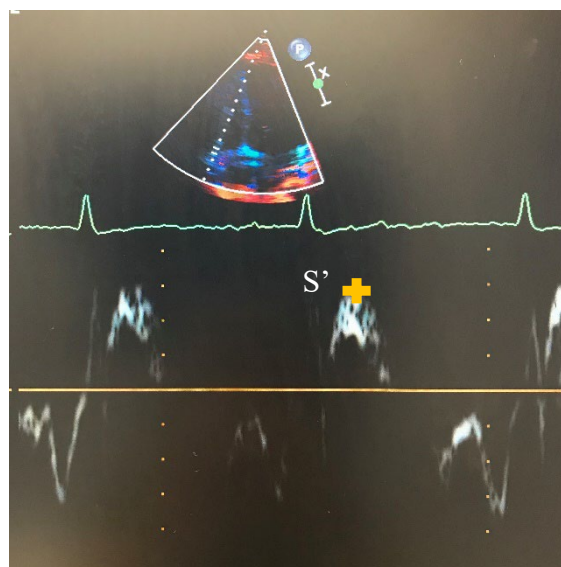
Tissue doppler imaging of the lateral tricuspid annulus S'
